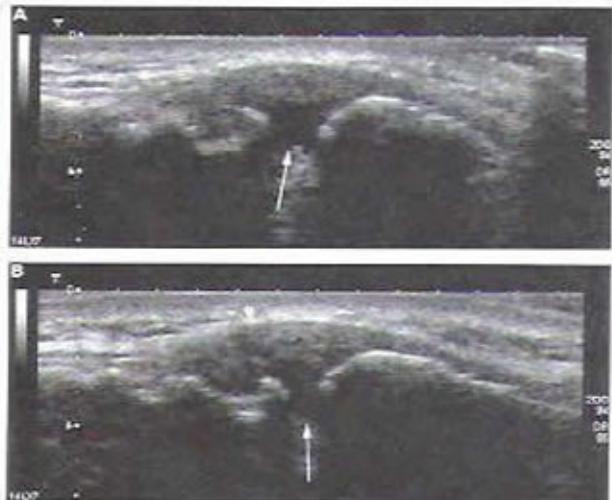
Sonograms of a normal AC joint during cross-arm maneuver. (A) Normal appearance in the resting position. Note the normal distance between the acromion and the clavicle and the normal capsule (arrowheads). (B) Sonogram in the cross-arm position shows minimal narrowing of the joint space with no change in the capsule (arrowheads).
